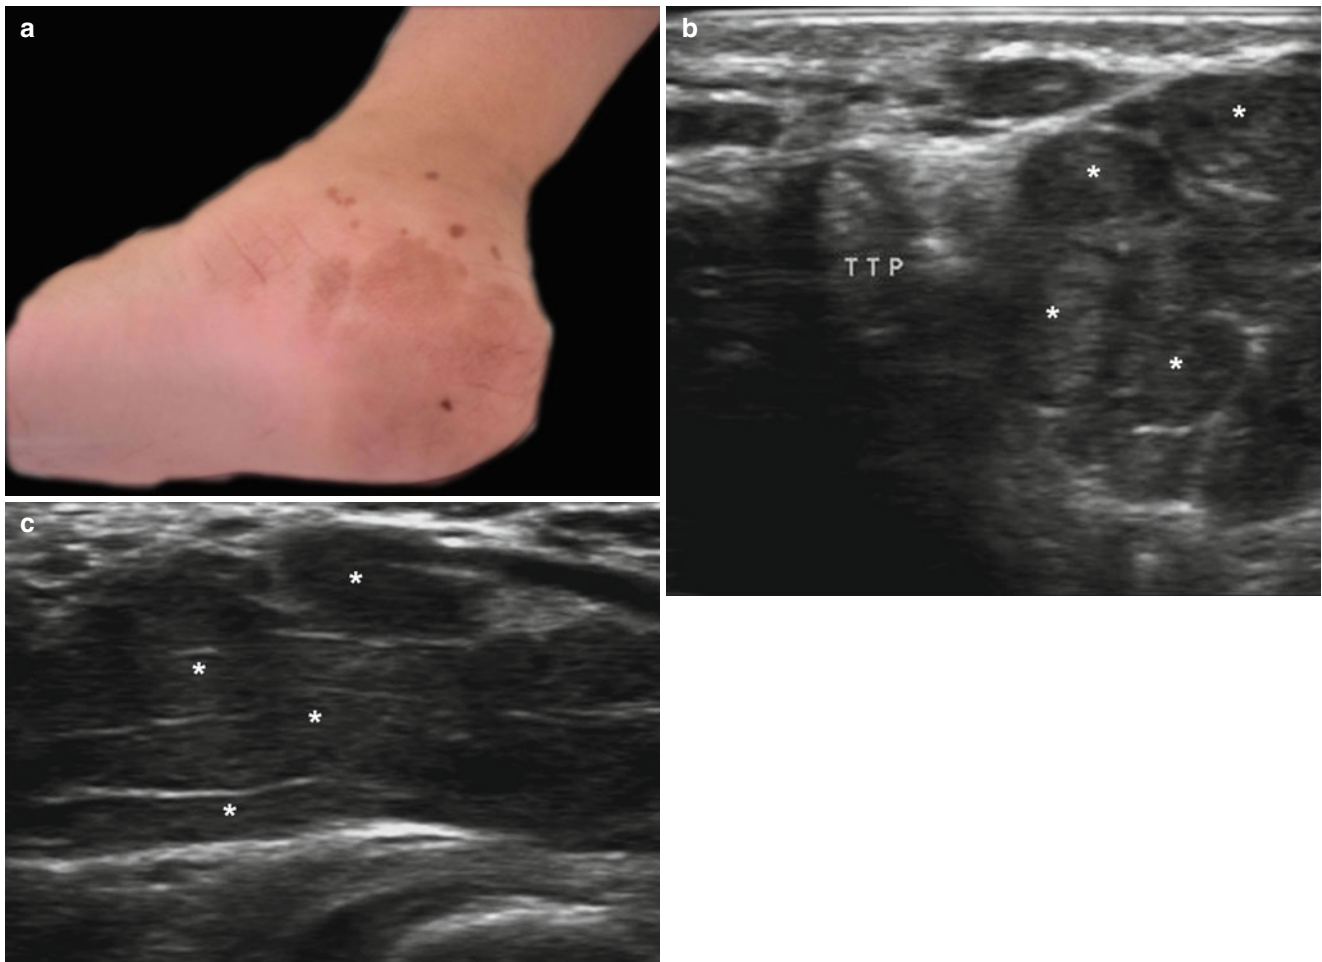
(a–c) Plexiform neurofibroma. (a) Clinical image of child with café-au-lait spots in the medial aspect of the ankle. The child presented difficulties for walking. (b) Ultrasound image (gray scale, transverse view, medial aspect of the ankle) shows multiple hypoechoic
